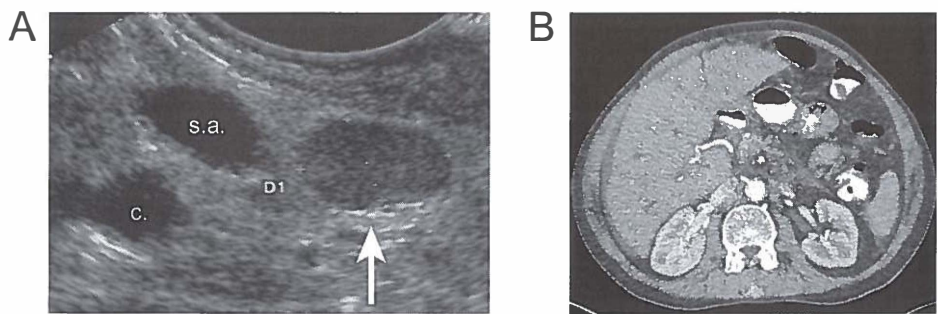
Patient with a small, 0.6 x 0.9 cm, metastasized glucagonoma, presenting with diabetes mellitus, icterus and a rash. A) Endoscopic ultrasound, showing the pancreatic tumor (arrow). On the left adjacent to the tumor the splenic artery (s.a.) and the hepatocaval confluence (c) are visible. B) The lesion is not visualized by computer tomography.
